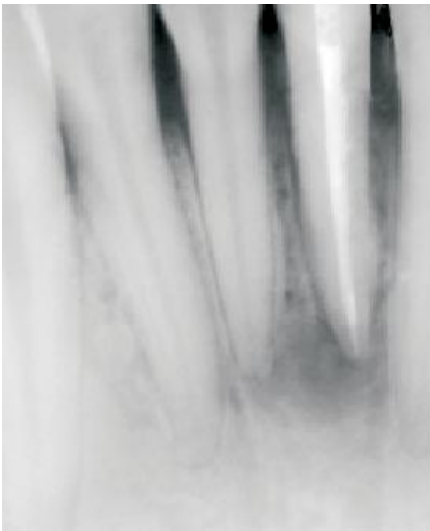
b. Radiograph - review after 6 months.
